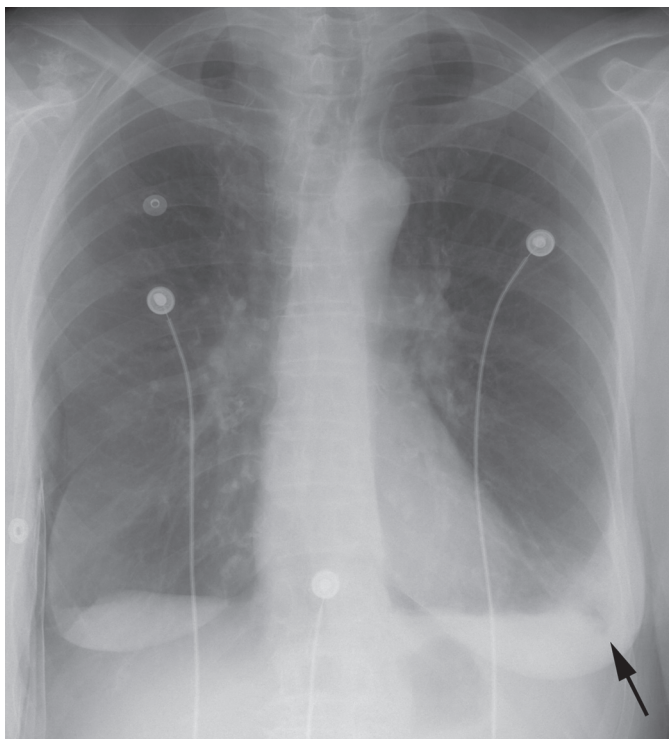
Pulmonary infarct. Frontal chest radiograph reveals wedge-shaped area of air-space disease in left costophrenic sulcus (arrow), also known as Hampton's Hump.
